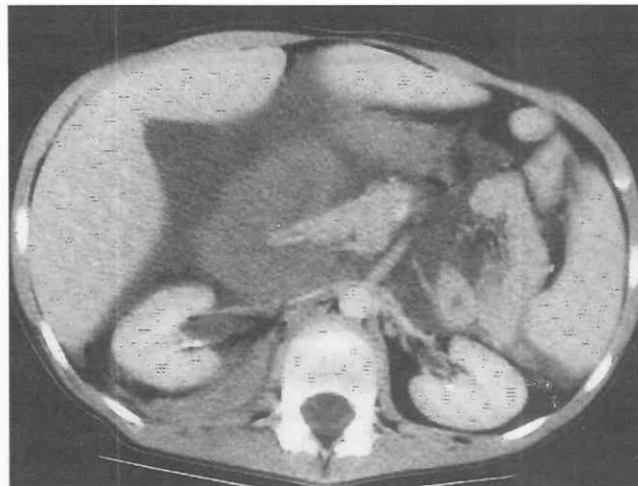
Clotted blood (sentinel clot). CT scan through the midabdomen in a patient following blunt abdominal trauma shows a well-circumscribed mesenteric hematoma. The hematoma has higher attenuation than free hemoperitoneum.
